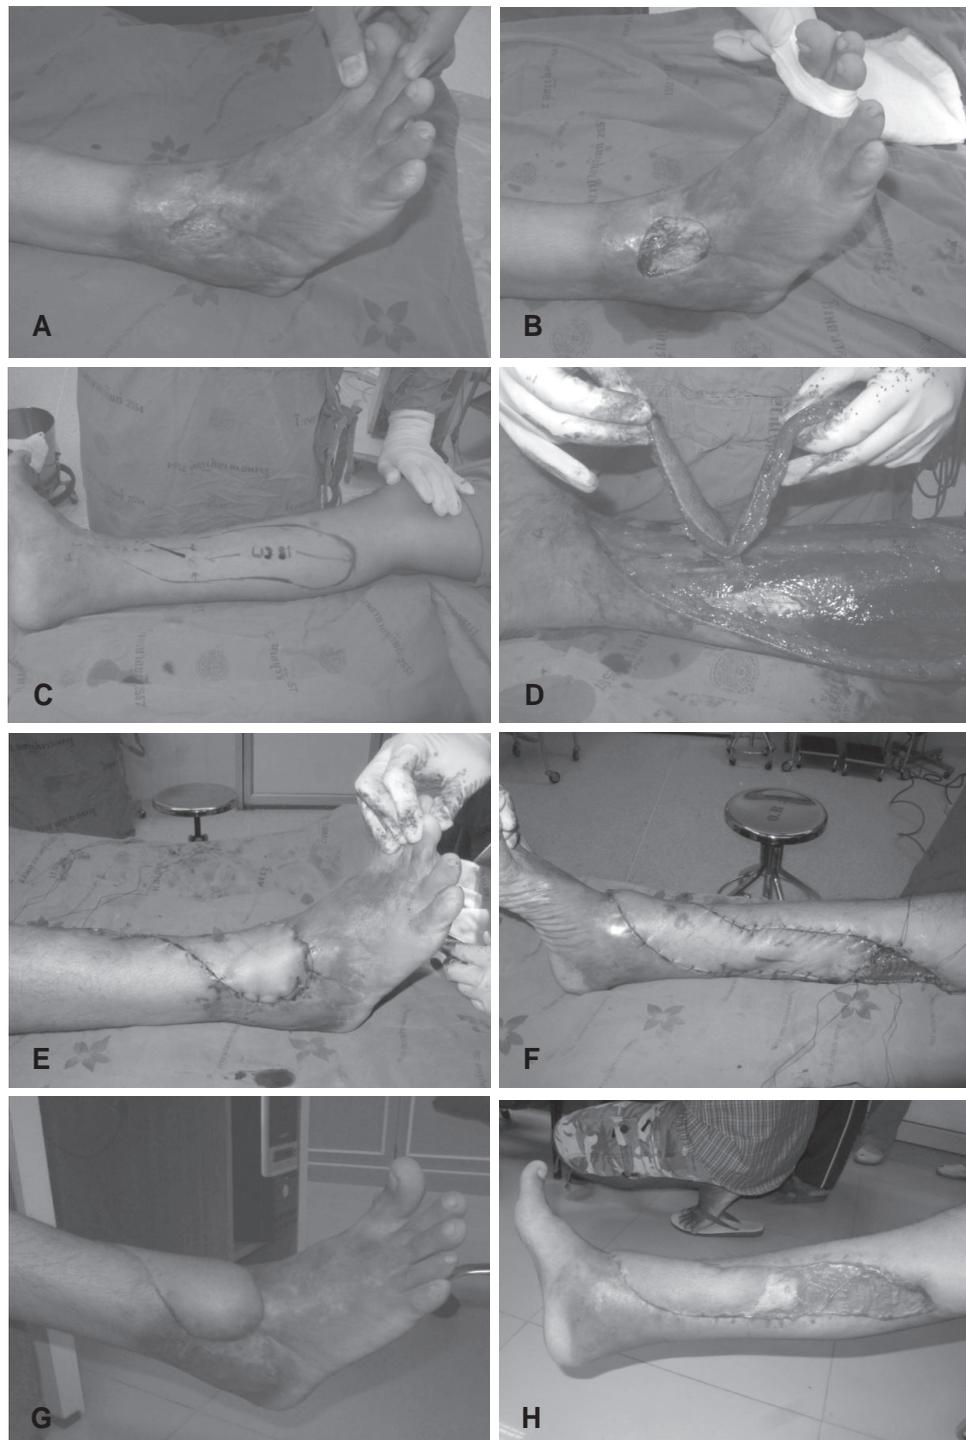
(A) Chronic ulcer over anterolateral ankle. (B) Soft tissue defect after debridement. (C) A design of propeller flap and marking of perforator by hand held Doppler ultrasound. (D) Flap harvesting and intraoperative view of septocutaneous perforator. (E) The flap was rotated 180° to cover the defect. (F) Donor site was covered by split-thickness skin graft. (G,H) Two months after surgery.
